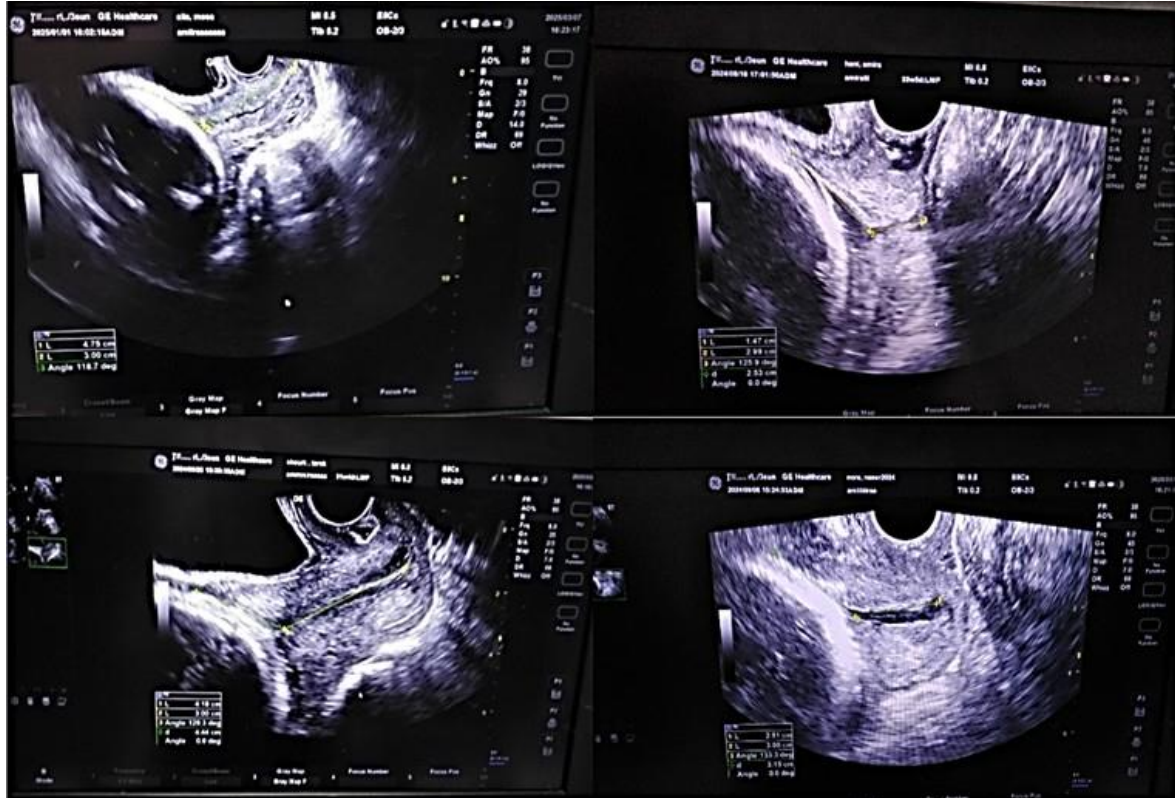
Ultrasound of UCA and CL.
